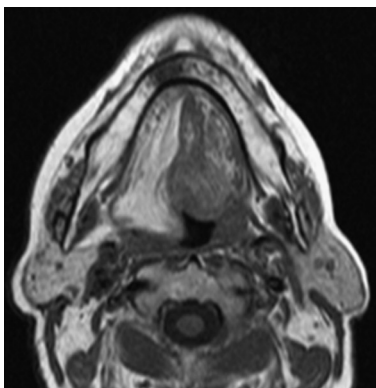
Magnetic resonance imaging spin echo T1 sequences in the axial plane.
